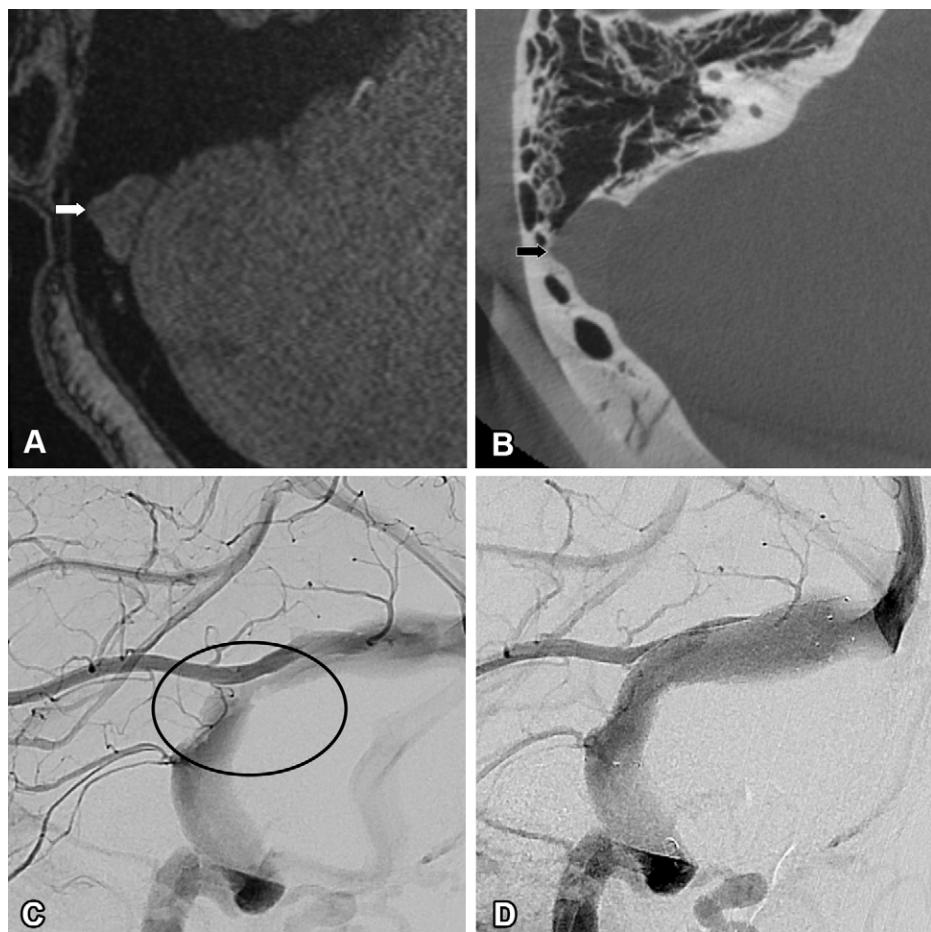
Left sigmoid sinus wall defect in a 29-year-old woman with bilateral tinnitus, subjective hearing loss with a normal audiogram, and imbalance. (A) Axial image from MR angiography performed to evaluate for a potential vascular lesion is retrospectively notable for subtle protrusion of the right sigmoid sinus wall (arrow). Conventional DSA was performed. (B) Axial image from 14-second flat-panel rotational CT of the temporal bone performed during DSA shows the sigmoid sinus wall defect (arrow). (C) Oblique angiogram obtained with right ICA injection in the venous phase shows irregularities of the transverse-sigmoid sinus junction (oval) with mild stenosis. The patient opted for stent placement. (D) Angiogram after stent placement shows no residual luminal irregularity. The patient experienced immediate resolution of her symptoms after the procedure.
